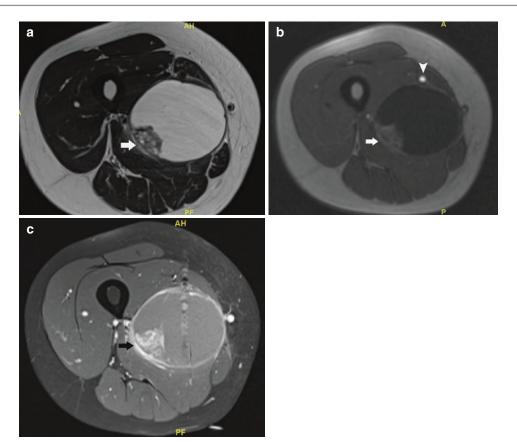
(a–c). High grade pleiomorphic sarcoma of the right adductor compartment in a 54-year-old female: (a) Axial T2-weighted MR image showing a large inhomogeneous intramuscular lesion with myxoid and solid (*white arrow*) components; (b) Axial dynamic MR sequence after intravenous bolus injection of gadolinium contrast showing very rapid enhancement of the solid part
